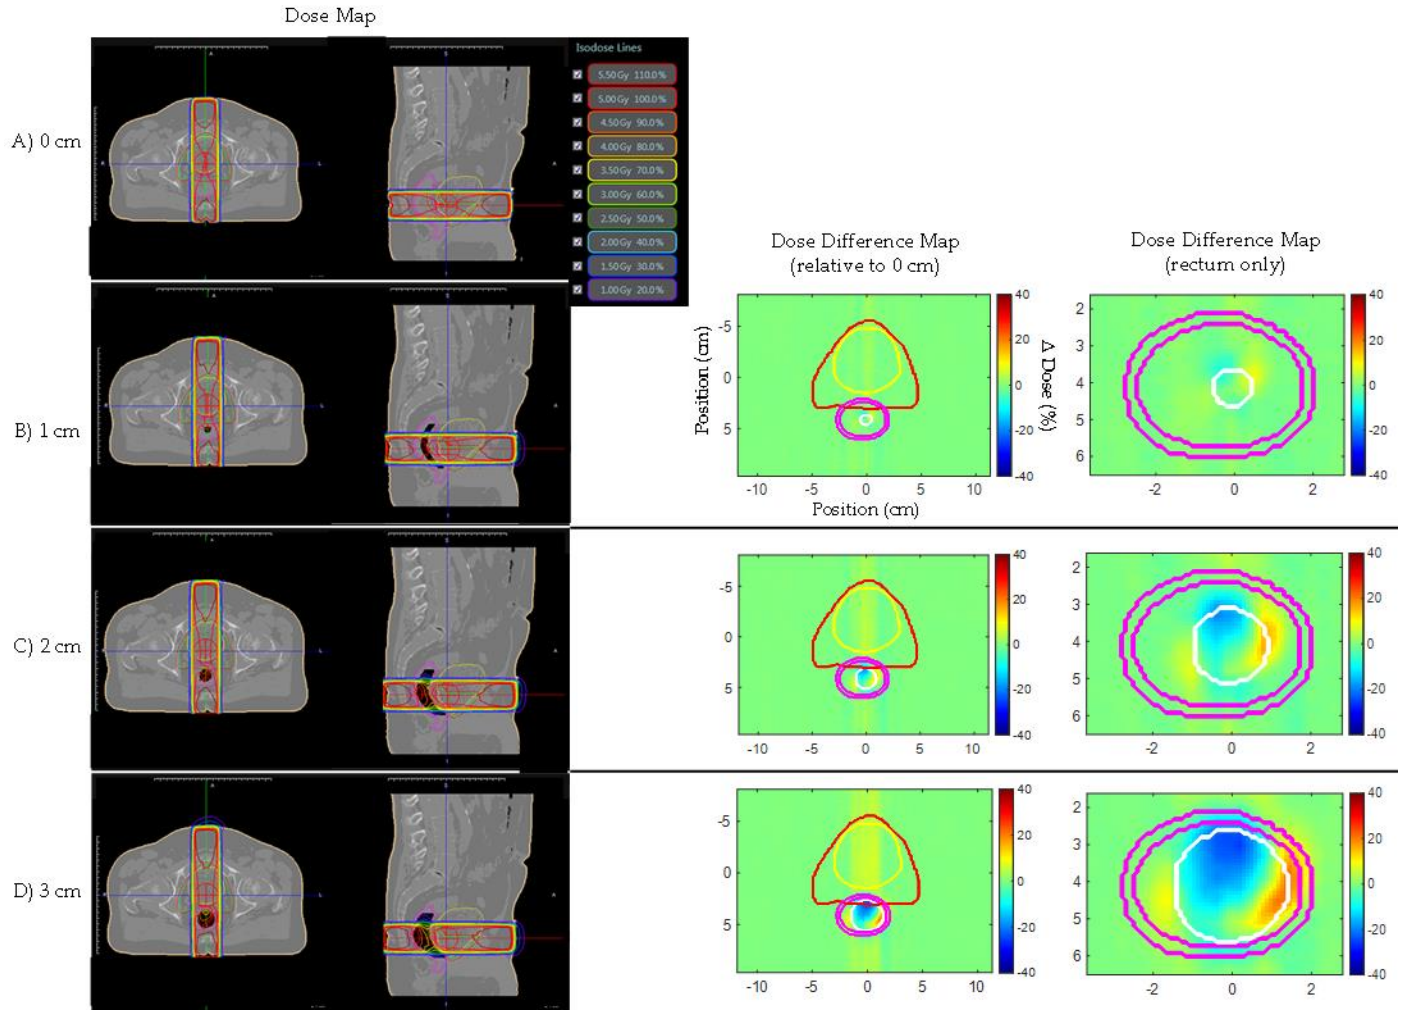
Prostate bed Patient A's AP-PA plan dose maps (overlaid on planning CT electron density map) and dose difference (Δ Dose (%)) maps for (A) 0, (B) 1, (C) 2, and (D) 3 cm artificial planning CT air cavity. Rectum dose difference maps show hot and cold spots within the rectum increased in magnitude and size with increasing air cavity size due to the electron return effect (ERE). Dose difference map planning CT contours displayed: Red—PTV; Yellow—bladder; Pink—rectum; White—artificial air cavity.
